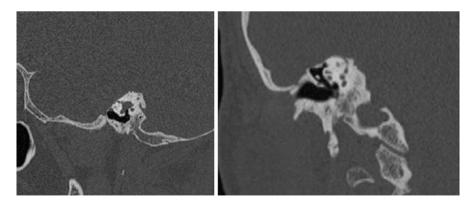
High-resolution computed tomography scans in coronal and sagittal views show superior semicircular canal dehiscence in a 45-year-old patient with tinnitus and vertigo who developed cerebrospinal fluid leak following repair. The patient also had an elevated intracranial pressure of $35 \text{ cm H}_2\text{O}$ consistent with idiopathic intracranial hypertension
